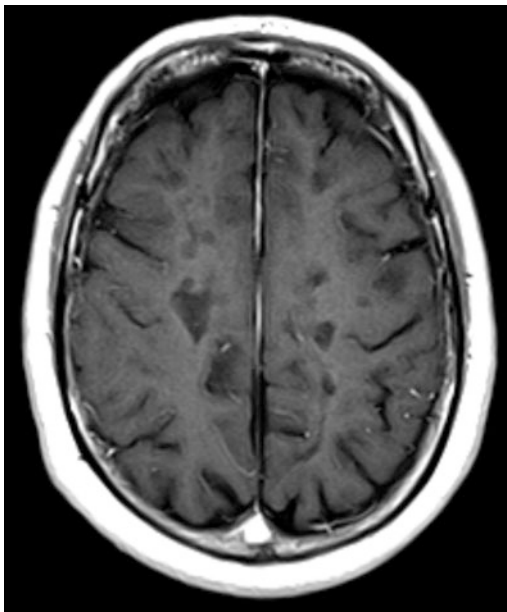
Axial T1-weighted magnetic resonance image with contrast showing hypointense multiple sclerosis lesions in the centrum semiovale bilaterally, without gadolinium enhancement, the so called “black holes”. These lesions are associated with axonal loss
